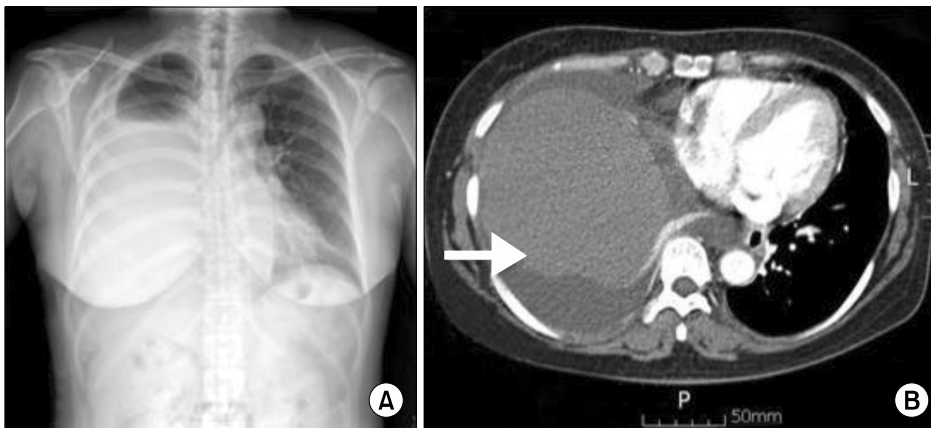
(A) Preoperative chest X-ray shows pleural effusion in the right lung field. (B) Preoperative computed tomograph scan shows a huge lobulated mass in the sub-phrenic area (arrow).
